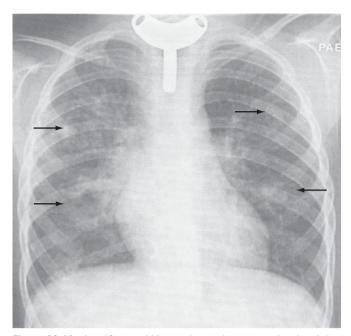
In a 13-year-old boy with a tracheostomy tube placed due to laryngeal papillomatosis, chest radiograph shows multiple nodular processes (*arrows*), some of which are cavitating, caused by parenchymal dissemination of the papillomatosis. (From Diagnostic imaging of the respiratory tract. In Chernick V, Boat TF, Wilmott RW, Bush A [eds]: Kendig's Disorders of the Respiratory Tract. Philadelphia, WB Saunders, 2006.)
